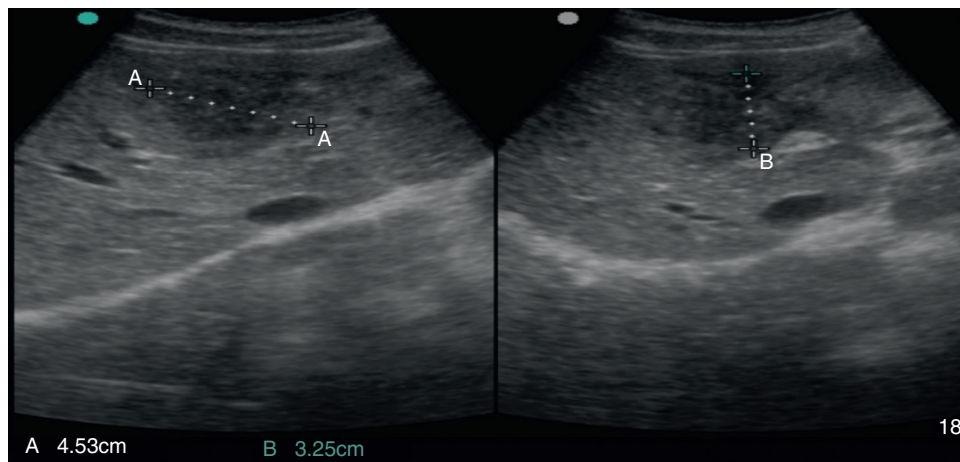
Abdominal ultrasound: pseudonodular lesion, hypoechoic, heterogeneous and partially undefined in segment IV of the liver.
